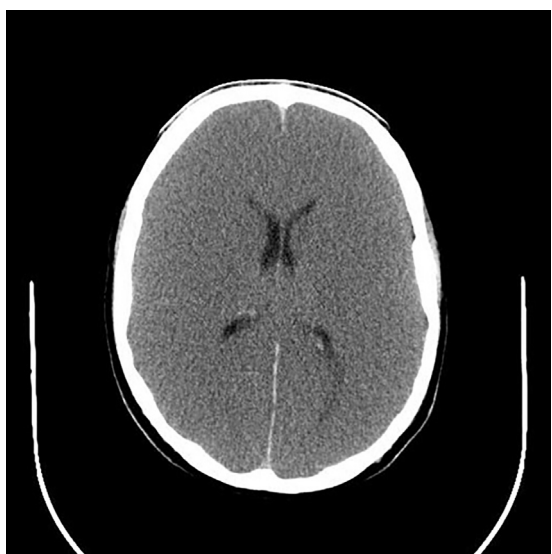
Computed tomography of the head without intravenous contrast medium. Diffuse loss of the gray-white differentiation accompanied by complete obliteration of the sulci and effacement of the lateral ventricles. These findings are consistent with diffuse anoxic brain injury with associated descending herniation.
